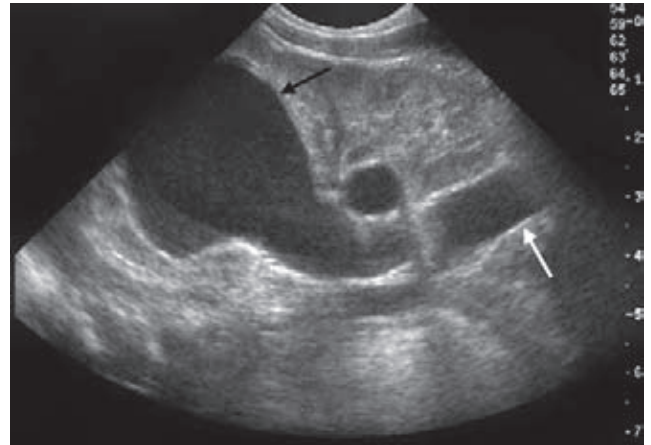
Ureteral duplication with obstructed upper renal moiety. Longitudinal ultrasound scan of left kidney shows a hydronephrotic upper moiety renal pelvis (white arrow) and its associated hydroureter (white arrows)
